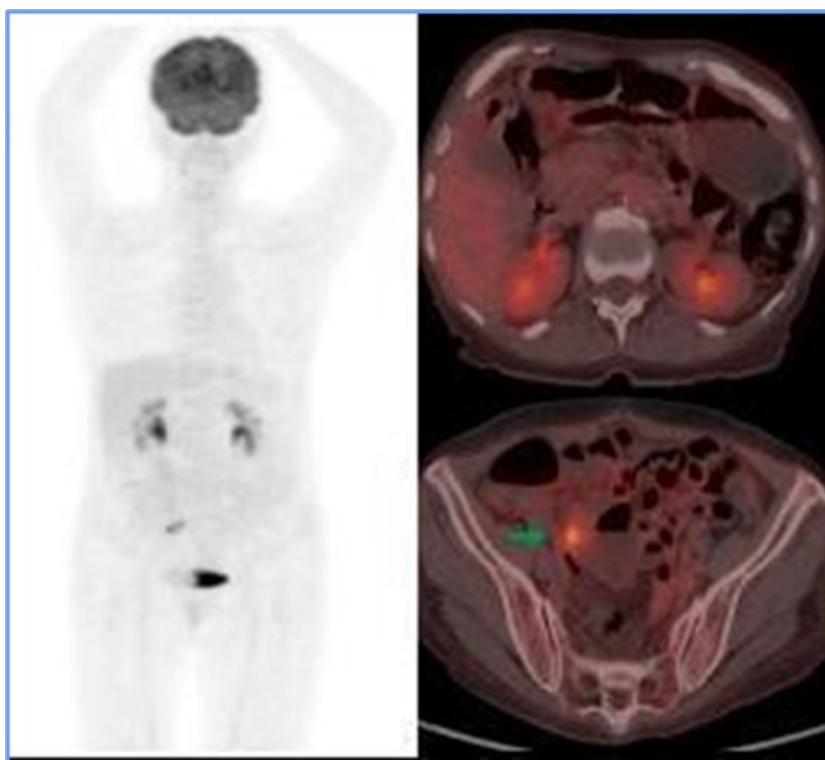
PET CT before ICE regimen. Only the right internal iliac chain adenopathy was evident (green arrow), which showed FDG uptake, exceeding hepatic uptake about score 4 of the Deauville criteria, suggesting a partial metabolic response to the medical treatment instituted.
